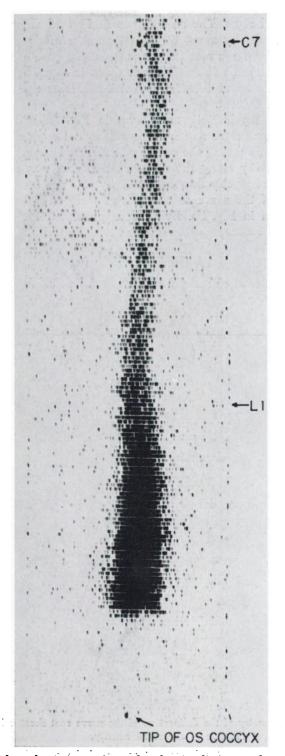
Normal myeloscintigram 6 months after irradiation to obstructing lesion at T5.
